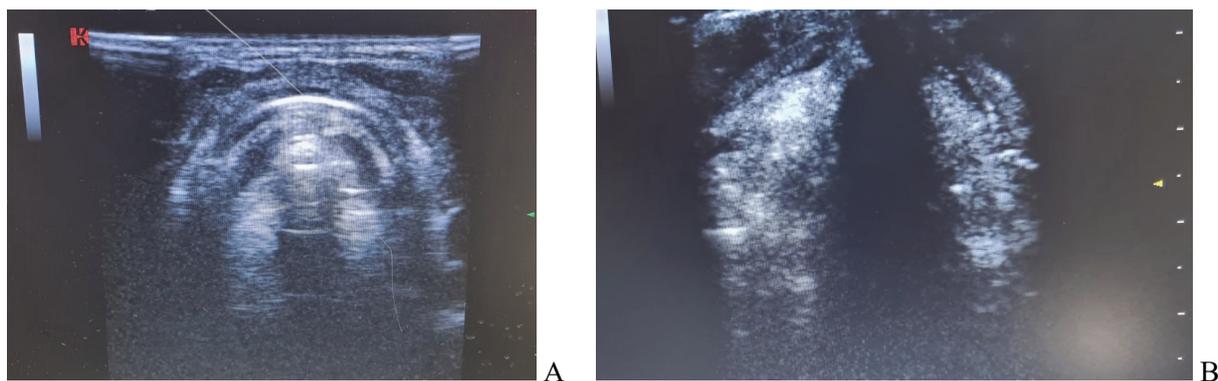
Normal ultrasound picture of the laryngeal soft tissues and vocal cords. A – glottis closing stage; B – glottis opening stage.
